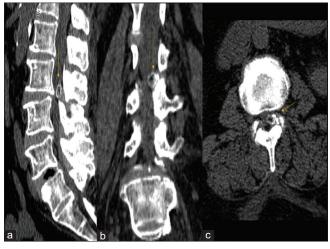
(a) Sagittal, (b) coronal, (c) axial non-contrasted cranial computed tomography sections showing a well-defined extra axial fat attenuating lesion at L2/L3 level on left side showing peripheral cortical rim. Associated degenerative changes are also noted.
